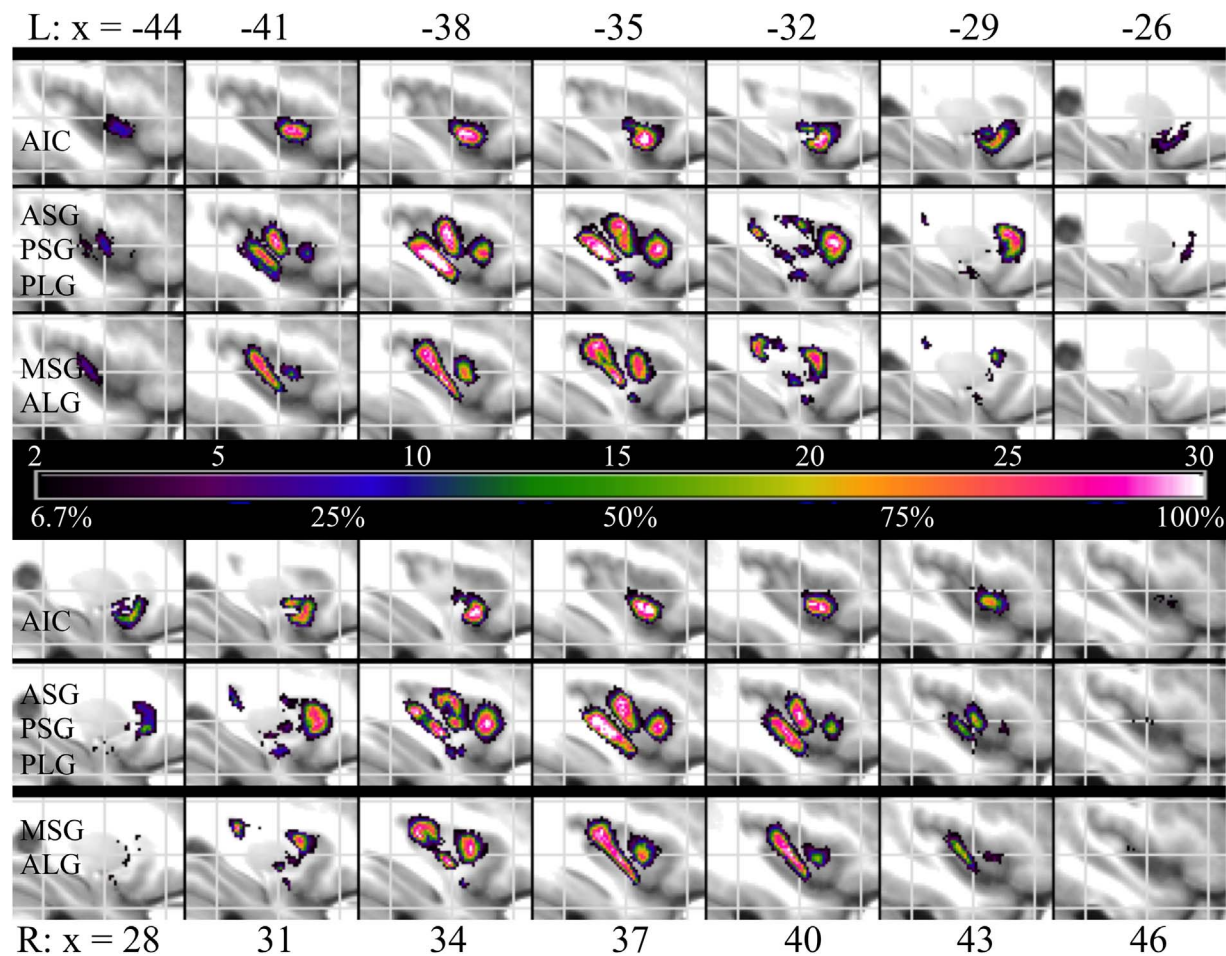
Probabilistic maps of subregions of left (L) and right (R) insula superimposed on the average of the 30 MR images in MNI152 space. Colors represent the prevalence of the various subregions at this location in number of subjects, as well as the probability of encountering the subregion as a percentage. Lines 1 and 4 represent the AIC; lines 2 and 5 represent ASG, PSG and PLG; lines 3 and 6 represent MSG and ALG. Gray lines indicate planes: $y=0$, $z=0$, $y= \pm 35\text{mm}$ and $z= \pm 30\text{ mm}$. x indicate the sagittal plane (mm from midsagittal plane).
